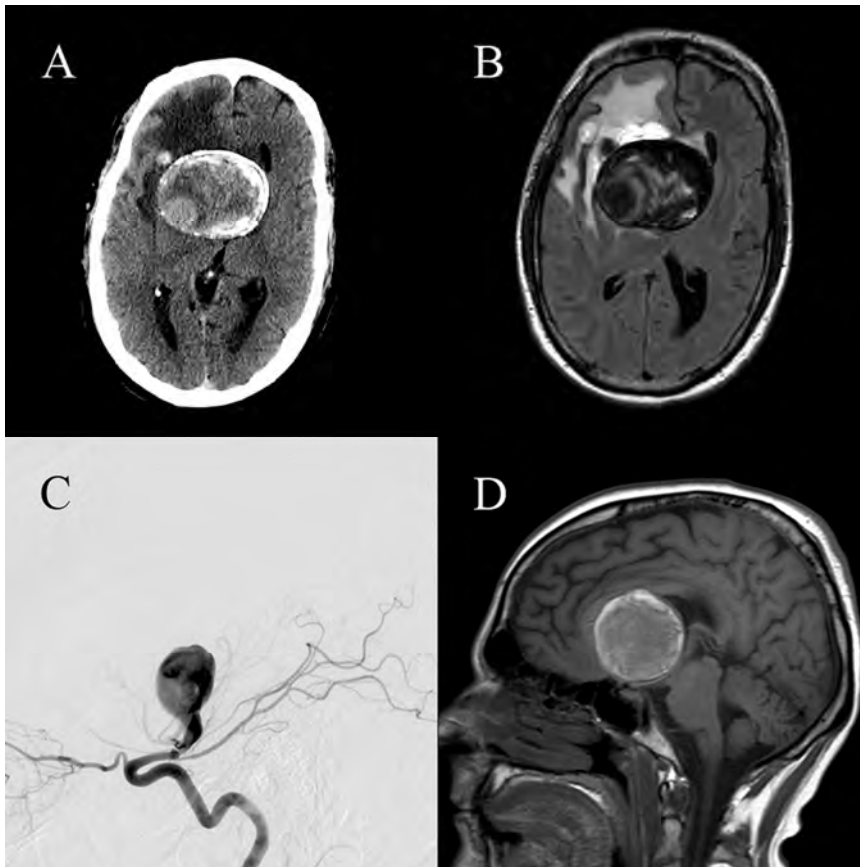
(A, B) Axial noncontrast computed tomography and axial fluid attenuated inversion recovery sequence magnetic resonance image (MRI), respectively, of the head of a 45-year-old man, showing a large supratentorial midline mass with thick rim of calcification and prominent vasogenic edema in right frontal lobe. (C) Conventional cerebral angiogram confirmed a giant partially thrombosed aneurysm at the origin of the right internal carotid artery bifurcation. (D) Sagittal T_1 sequence MRI of the head showing the large midline aneurysm compressing the thalamic and hypothalamic structures, as well as the superior anterior aspect of the brainstem.
